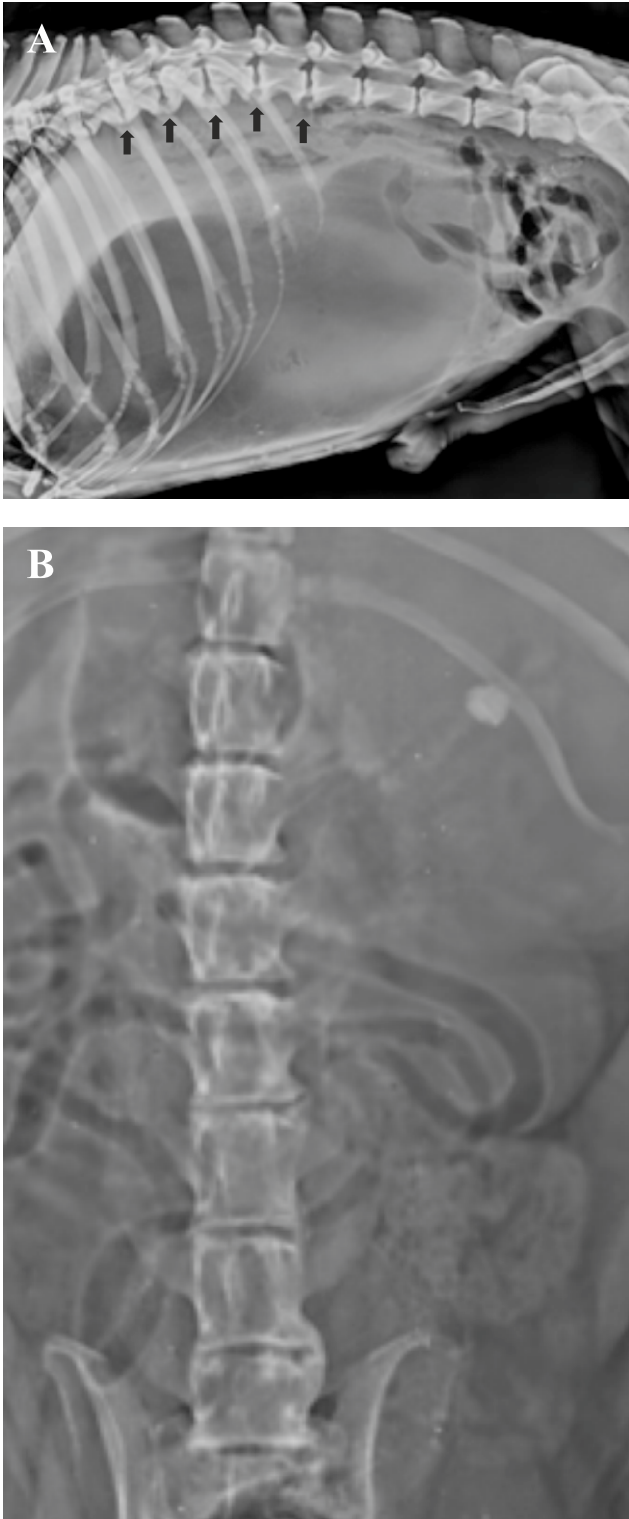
Lateral (A) and ventro-dorsal (B) radiographs of Case-4 demonstrating spondylosis deformans, Grade 3 (arrow)- enthesophytes bridging are located on the ventral aspect of the vertebral bodies of L1-L7.
